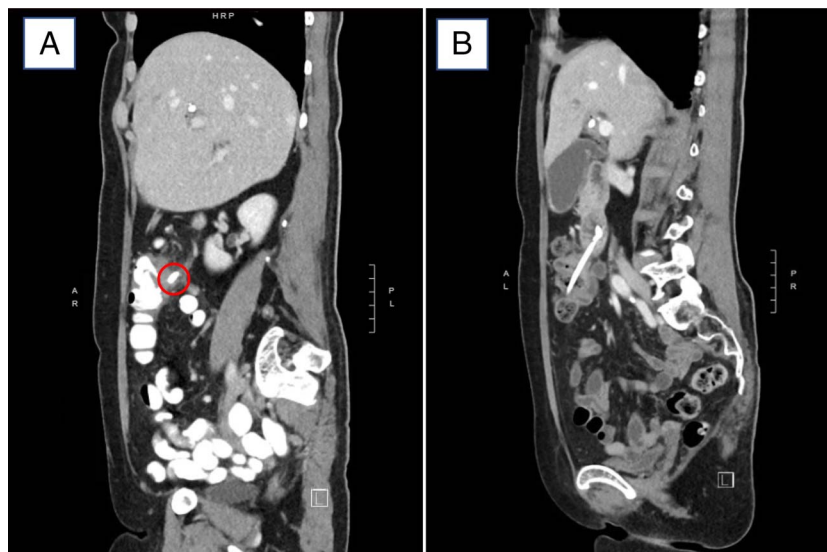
(A) Initial sagittal CT showing biliary stent (red circle) penetrating through duodenum and abutting the wall of the transverse colon with associated mural thickening and inflammatory stranding, but no evidence of perforation. (B) Follow-up sagittal CT showing biliary stent penetrating through duodenum into transverse colon. CT, computed tomography.
